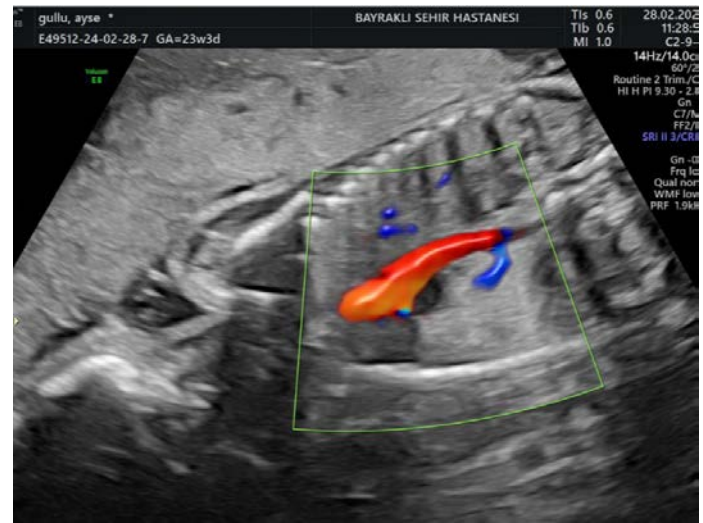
Doppler ultrasound of the patient showing vascularization of the mass originating from the fetal aorta.
